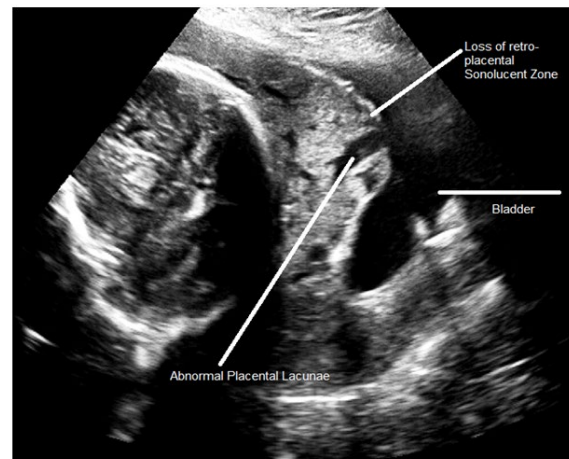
2D gray scale ultrasound scan shows loss of retro-placental sonolucent zone and abnormal placental lacunae in morbid adherent placenta.
